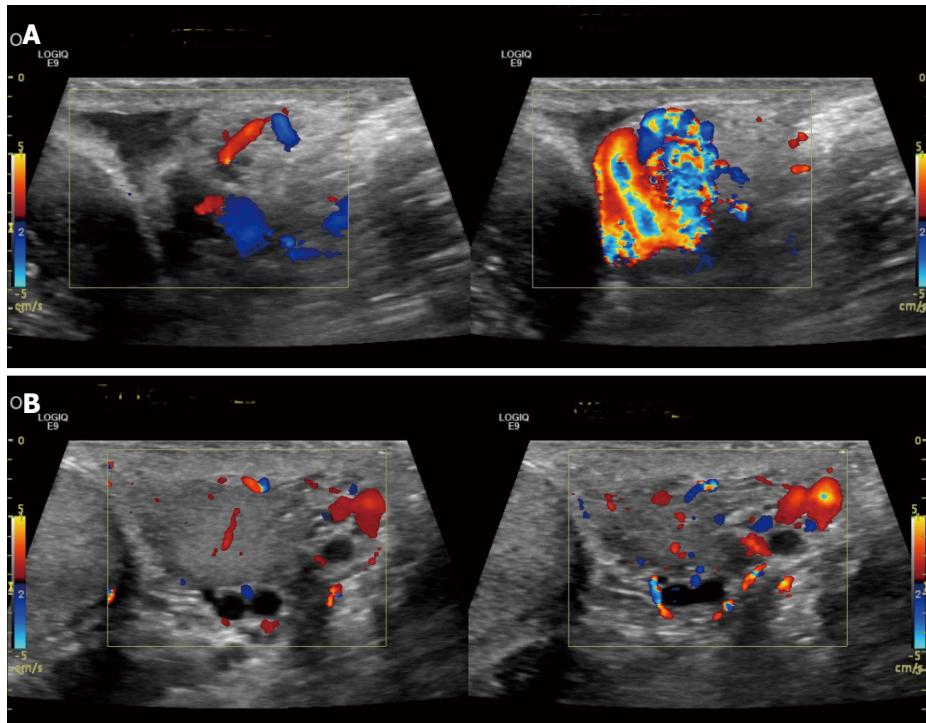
A 36-year-old man with left varicocele. Color Doppler sonographic images, longitudinal sections at the level of the upper (A) and lower pole (B) of the left testis depict blow flow reversal seen during the Valsalva maneuver.
